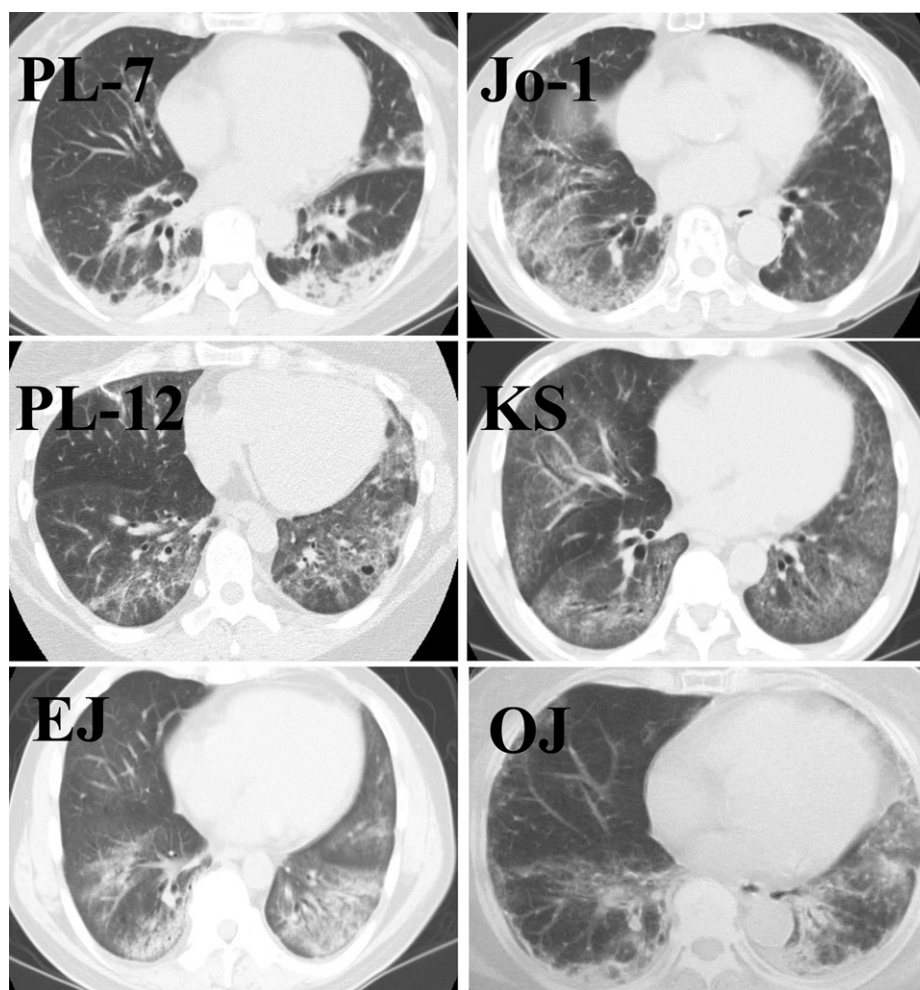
Representative chest computed tomography (CT) findings for patients with different anti-ARS antibodies. Every chest CT demonstrates bilateral ground-glass opacities and linear and reticular shadows in the lower lobes, predominantly subpleural.
